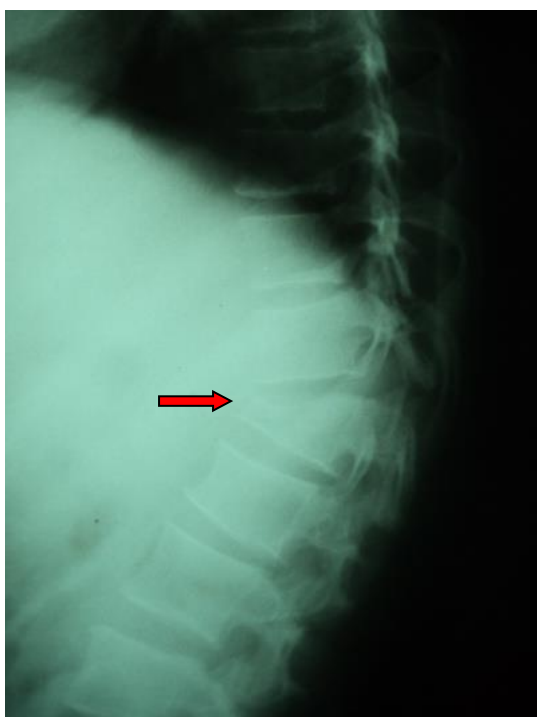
Radiograph of the spine lateral view showing wedge indicated by arrow
